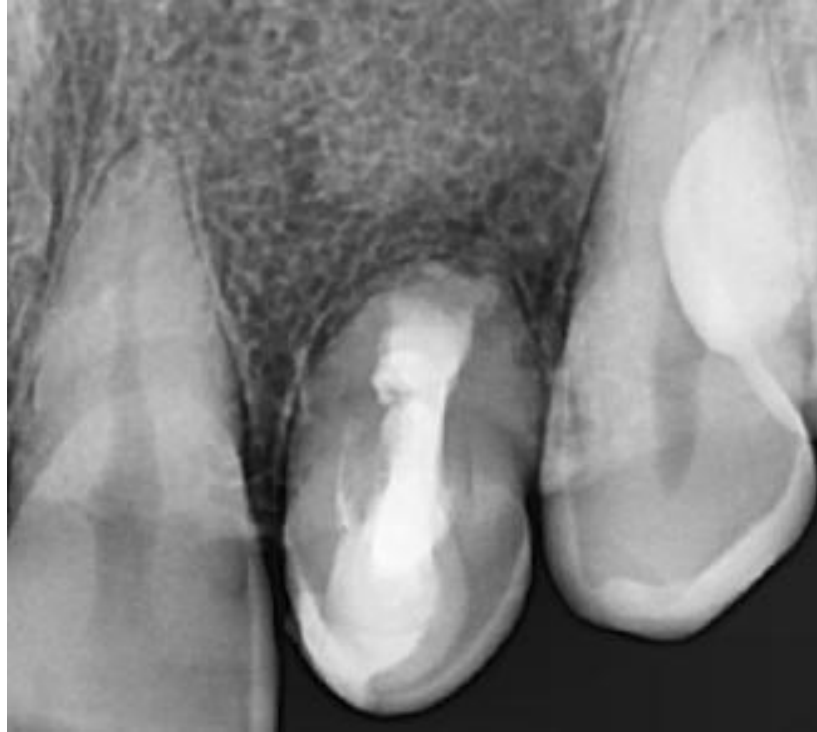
Periapical radiograph after root canal obturation
